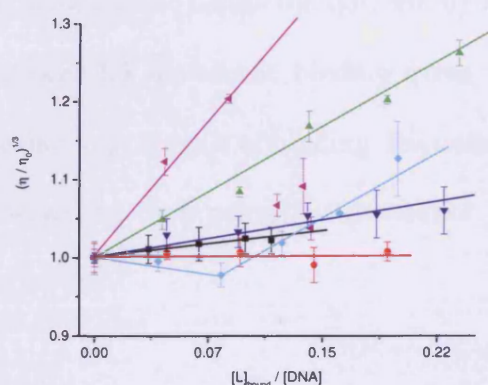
Relative viscosity of a 0.5 mM CT DNA solution upon addition of 5.1 (■), 5.4 (◄), 5.5 (▼), 5.6 (●), H33258 (●) and ethidium bromide (▲) at 25 °C in 25 mM MOPS pH 7.0, 50 mM NaCl, 1mM EDTA.
